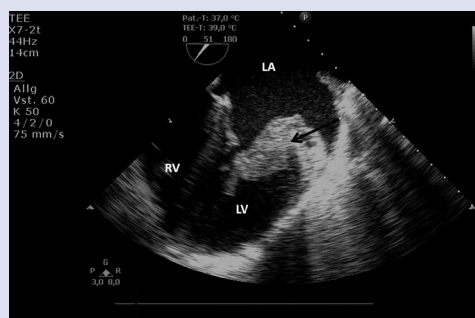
Two-dimensional transoesophageal echocardiographic examination, midesophageal four-chamber view. The hyperechoic structure on the mitral valve is to be seen; abbreviations as in Figure 1
